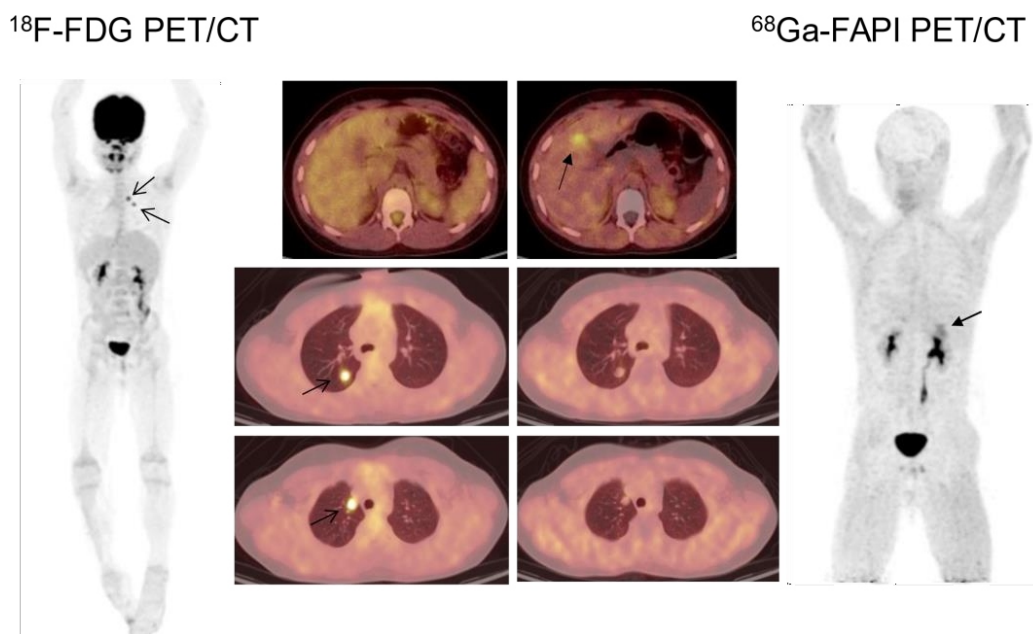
A known case of Ewing sarcoma (involving the left fibula) underwent surgical resection and chemotherapy. No abnormal hypermetabolic lesion existed at the surgical bed (left fibula). Hypermetabolic pulmonary nodule in the RUL with no FAPI uptake was indicated. Hypermetabolic right paratracheal lymph node without FAPI uptake. Discordance between ^{18}F -FDG and FAPI uptake in pulmonary nodule (RUL) and paratracheal lymph node required tissue sampling in order to exclude metastatic involvement. In addition, increased ^{68}Ga -FAPI liver uptake was observed with ^{18}F -FDG non-avidity (upper transverse images).
